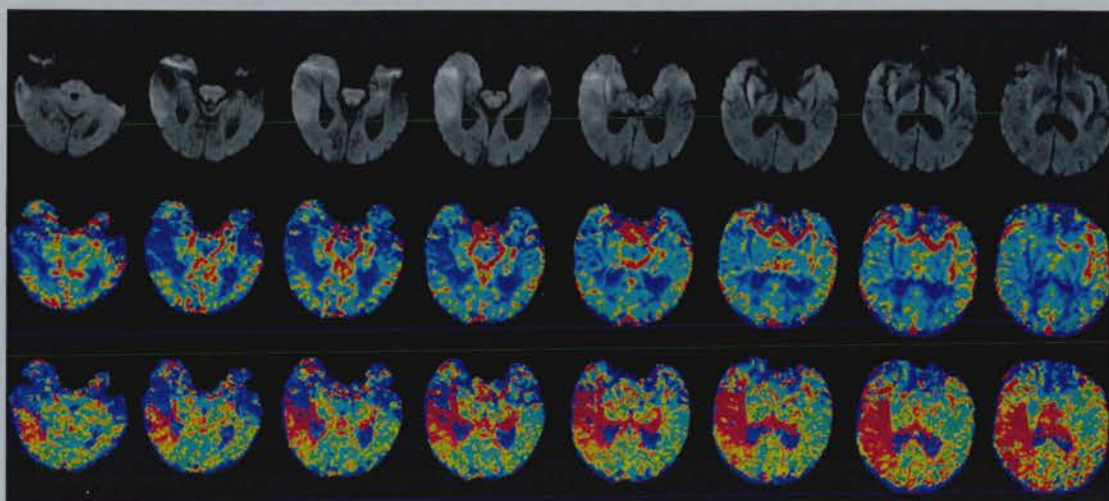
A large PI-DWI mismatch
